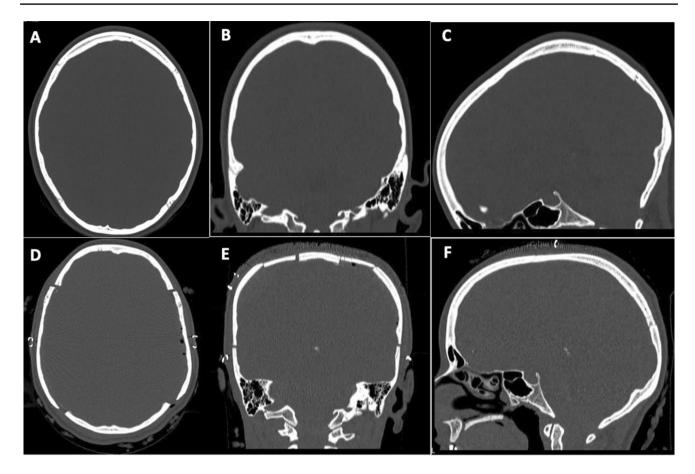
CT scan (bone sequences) of patient 19 before (A-C) and after (D-F) cranial vault expansion (axial, coronal and sagittal view)
